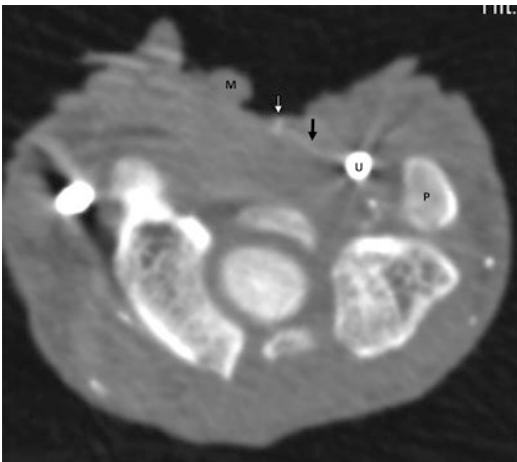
Intraoperative computed tomography (CT) angiogram at the level of the pisiformis after performing external neurolysis of the median nerve (Artis Zeego, Siemens AG, Germany). The direct branch of the ulnar artery to the flexor synovium is identified. *P* pisiform, *M* median nerve, *U* ulnar artery, *Large arrow* the direct branch of the ulnar artery to the flexor synovium, *Small arrow* artery in the flexor synovium
